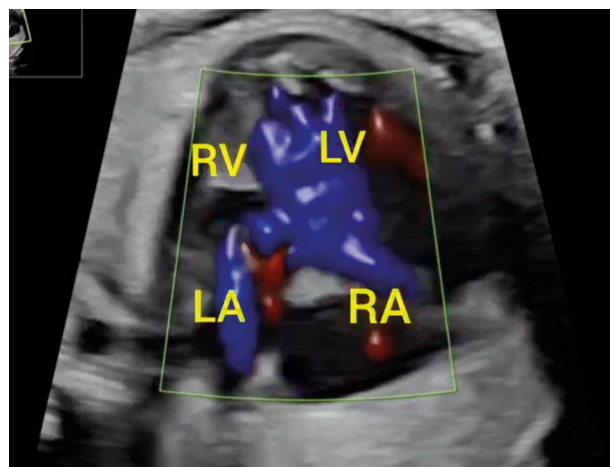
Criss-cross heart with congenitally corrected transposition of the great arteries: color Doppler blood flows from the left atrium through the tricuspid valve was directed to the right ventricle, from the right atrium through the mitral valve directly to the left ventricle, from the right atrium indirectly through the large VSD to the right ventricle and the blood was mixed between the ventricles
